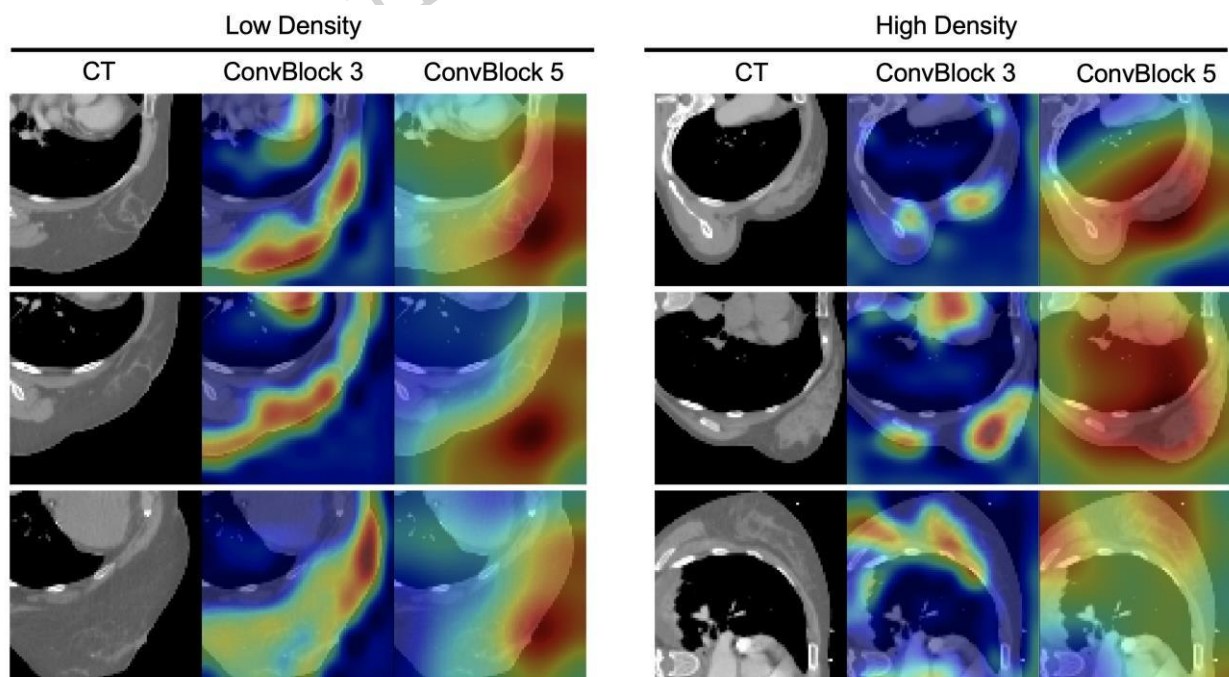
Grad-CAM saliency mapping for low (left) and high (right) density classes at the level of the third and fifth convolutional blocks, for representative CT images.
